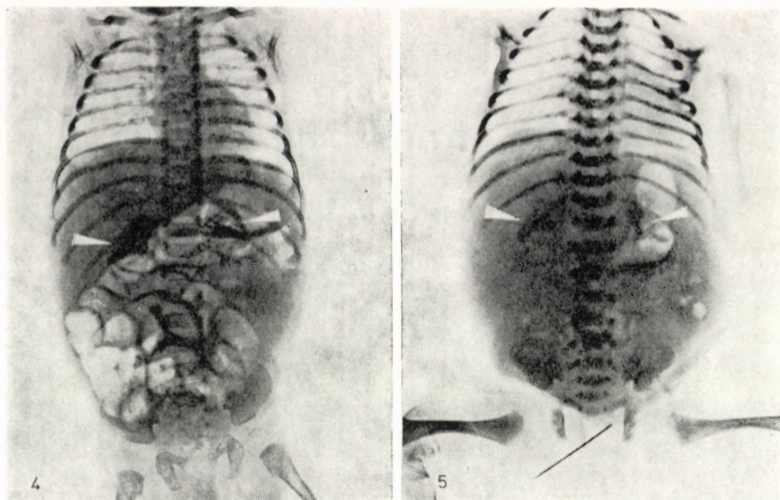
Plain abdominal X-ray of twin B at two weeks of age. Pronounced calcification in the right adrenal region, on the left side it is covered by intestinal shadows. Hepatomegaly and bronchopneumonia can be observed
